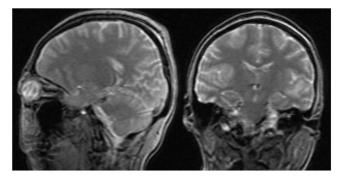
Magnetic Resonance Imaging (MRI) of the brain showing confluent areas of abnormal signal involving the bilateral frontal and temporal lobes as well as diffuse leptomeningeal enhancement.
